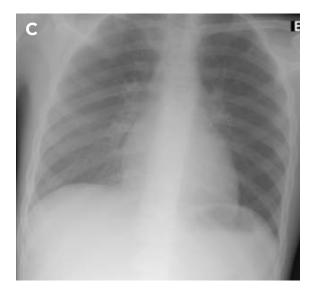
A, B – Chest x-ray with bilateral pulmonary infiltrates with bilateral pleural effusion. C – Chest x-ray with complete resolution of pleural effusion in five days.
